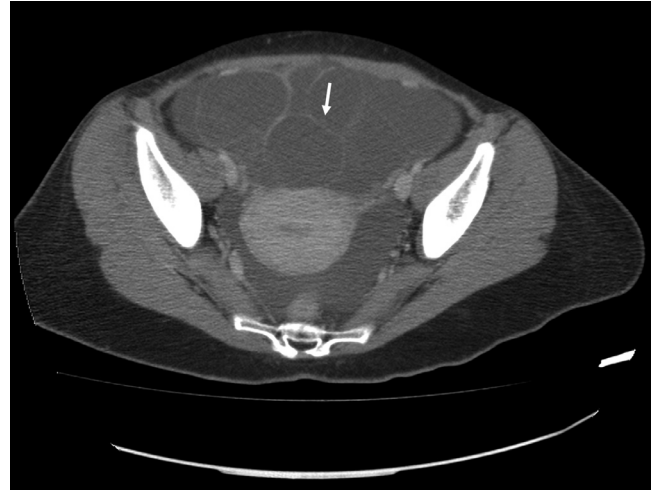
Adnexal multiloculated and multilobulated cystic masses. Axial contrast-enhanced CT image, venous-phase, shows bilaterally enlarged ovaries with 2 multiloculated and multilobulated cystic masses, with thin septa and fluid attenuation values (range 2-15 HU) with few small solid intracystic nodules (arrow).
